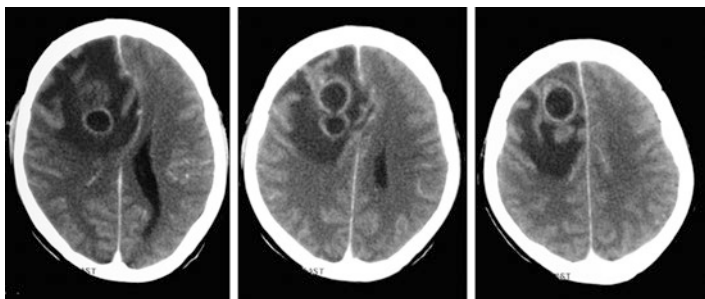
Contrast enhanced brain CT scan showing a brain abscess in a 38-year-old man on immunosuppression therapy for SLE. Note the smooth outline of the rings of enhancement
